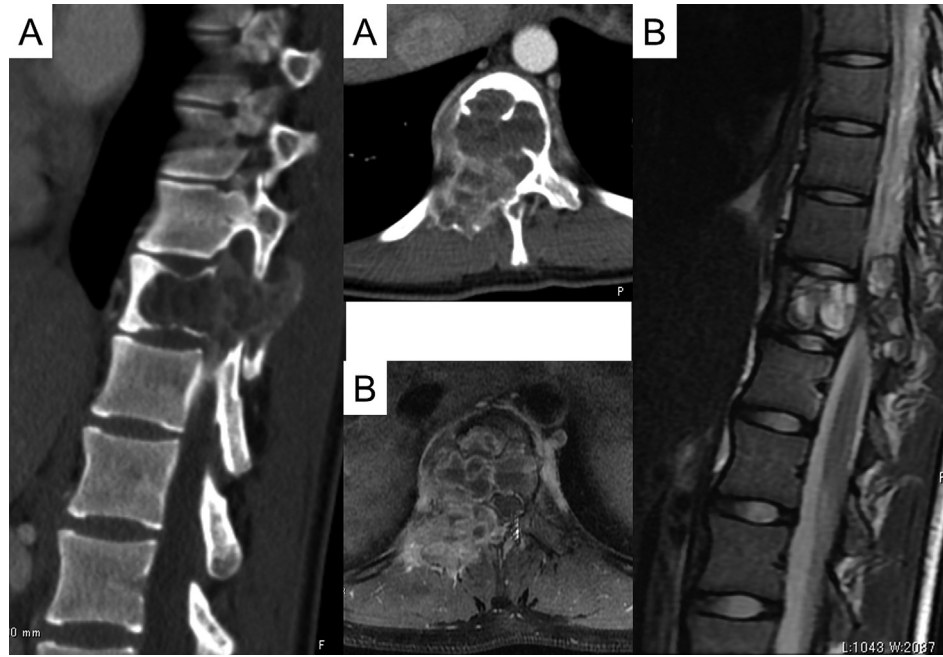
Preoperative images of the T11 tumor, A: sagittal and axial views of contrast computed tomography, B: sagittal and axial views of T2-weighted magnetic resonance imaging.
